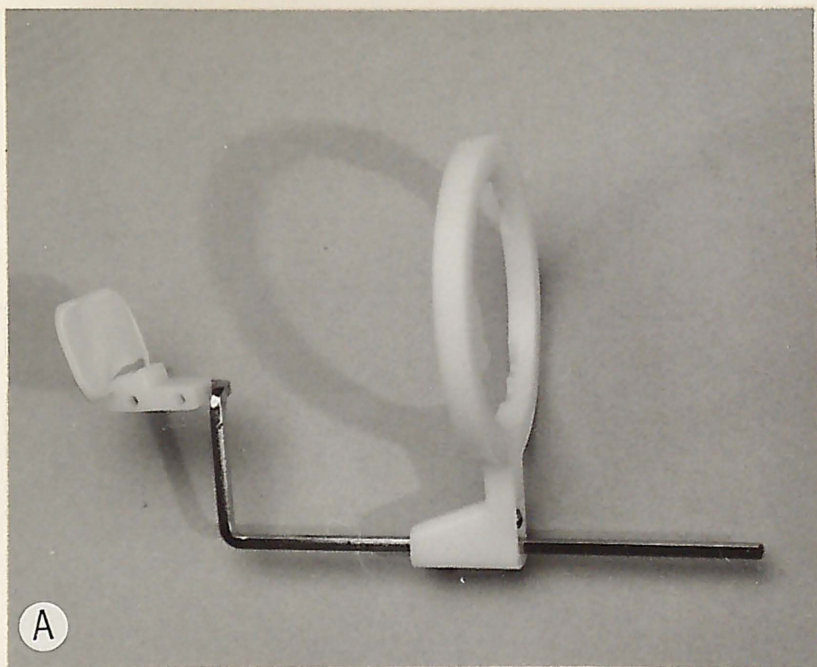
Clinical use of the bitewing film holder demonstrated.
